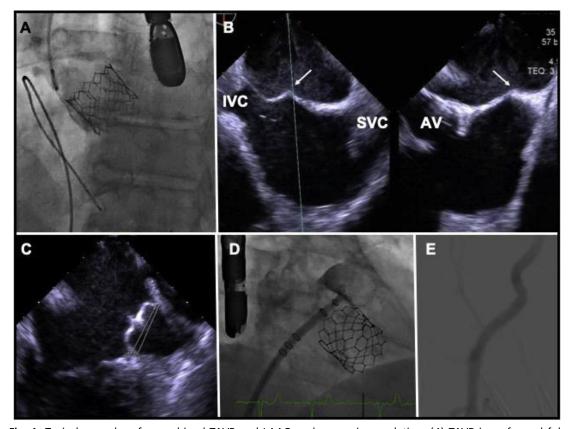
Typical procedure for combined TAVR and LAAO under conscious sedation. (*A*) TAVR is performed followed by introduction of the transesophageal echocardiography (TEE) probe. (*B*) Biplane TEE demonstrates typical inferior and posterior transseptal puncture. LAAO in position by (*C*) TEE and (*D*) fluoroscopy. (*E*) Removal of TAVR delivery sheath, LAAO delivery sheath, and femoral completion angiography.
